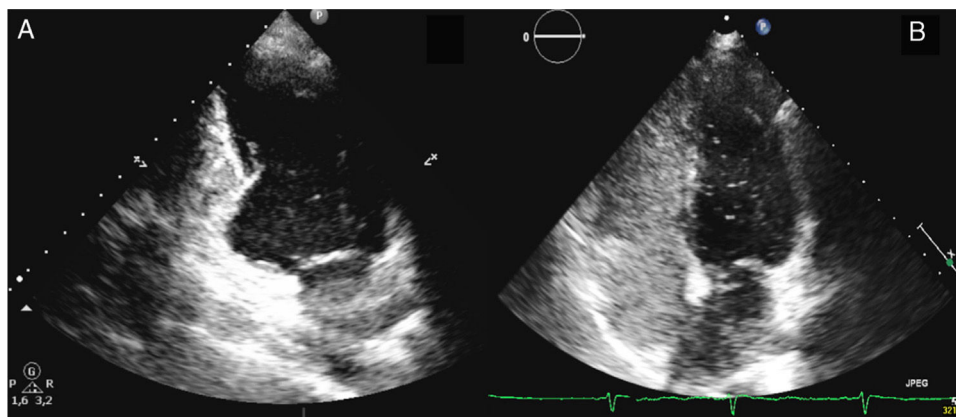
Transthoracic echocardiogram. A) Two-chamber view showing a congenital left ventricular outpouching in the inferobasal wall. B) Right-to-left shunt was demonstrated by the passage of bubbles after the injection of agitated saline solution.
